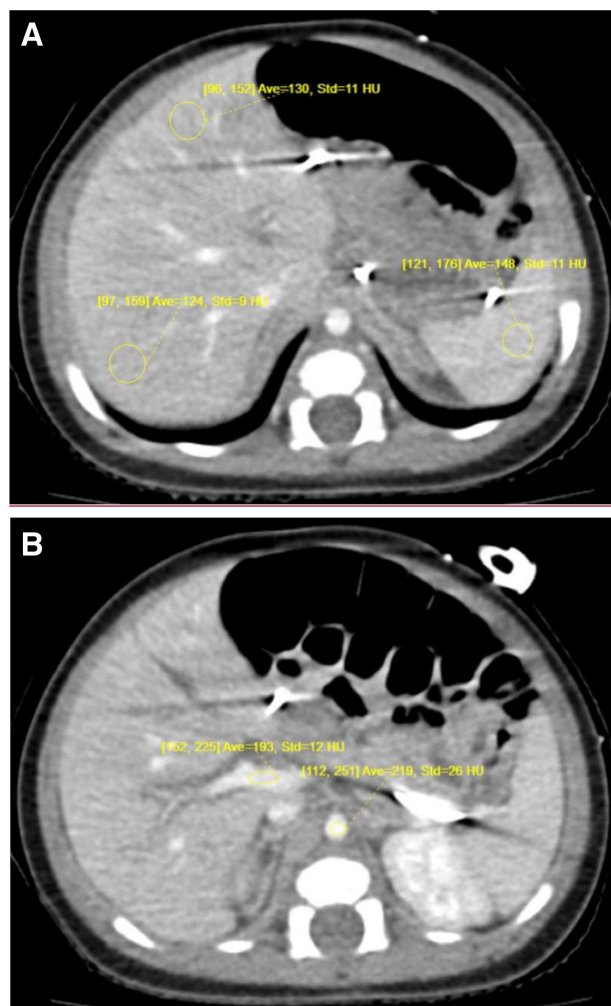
Example image measurement is shown. Similar sized regions of interest (yellow ovals) were measured on the same axial slice. Measurement of liver and spleen parenchymal attenuation (A) and main portal vein and abdominal aorta (B) on axial CT images obtained of a 2-mo-old Caucasian boy with hepatic steatosis. CT = computed tomography; HU = Hounsfield units.
